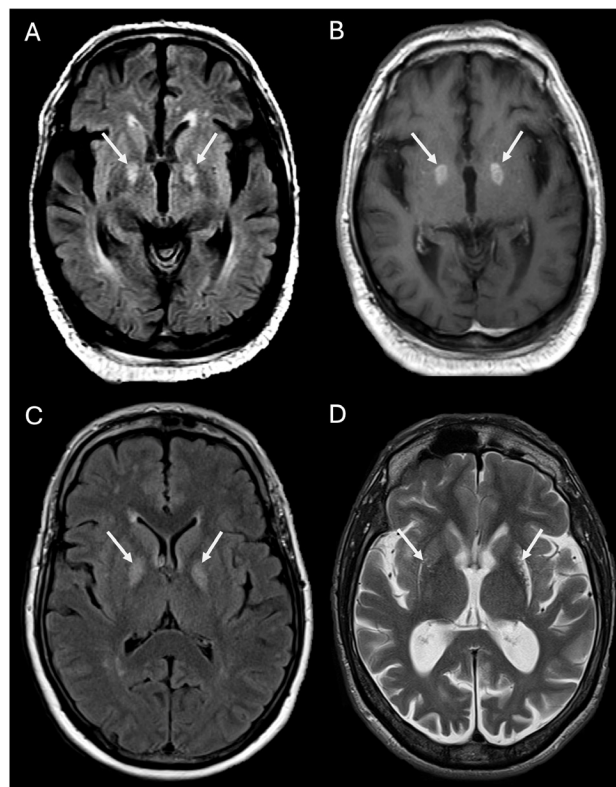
MR scans of brain. Axial FLAIR sequence (A) and postcontrast T1-weighted (B) in a patient in their 50s with suspected carbon monoxide poisoning shows symmetrical high T2w/FLAIR signal in both globus pallidi with corresponding high T1w signal and enhancement suggesting necrosis (arrows). Axial FLAIR sequence (C) in a different patient in their 60s with suspected carbon monoxide poisoning showing similar bilateral abnormal pallidal signal (arrows). Axial T2w sequence in a patient in their 30s (D) 20 years after carbon monoxide poisoning shows a less common imaging finding of secondary mature damage in both putamina (arrows), plus symmetrical parieto-occipital predominant cerebral volume loss. FLAIR, fluid-attenuated inversion recovery.
